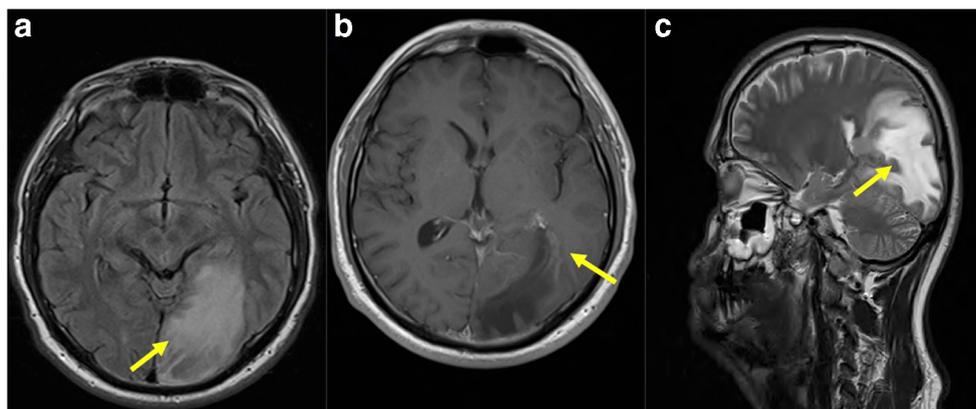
MRI brain scan from a patient presenting with a monophasic illness consisting of visual field loss, seizures and encephalopathy. a Axial fluid attenuated inversion recovery (FLAIR) image demonstrating high signal intensity abnormality in the occipital lobe, b T1-weighted
